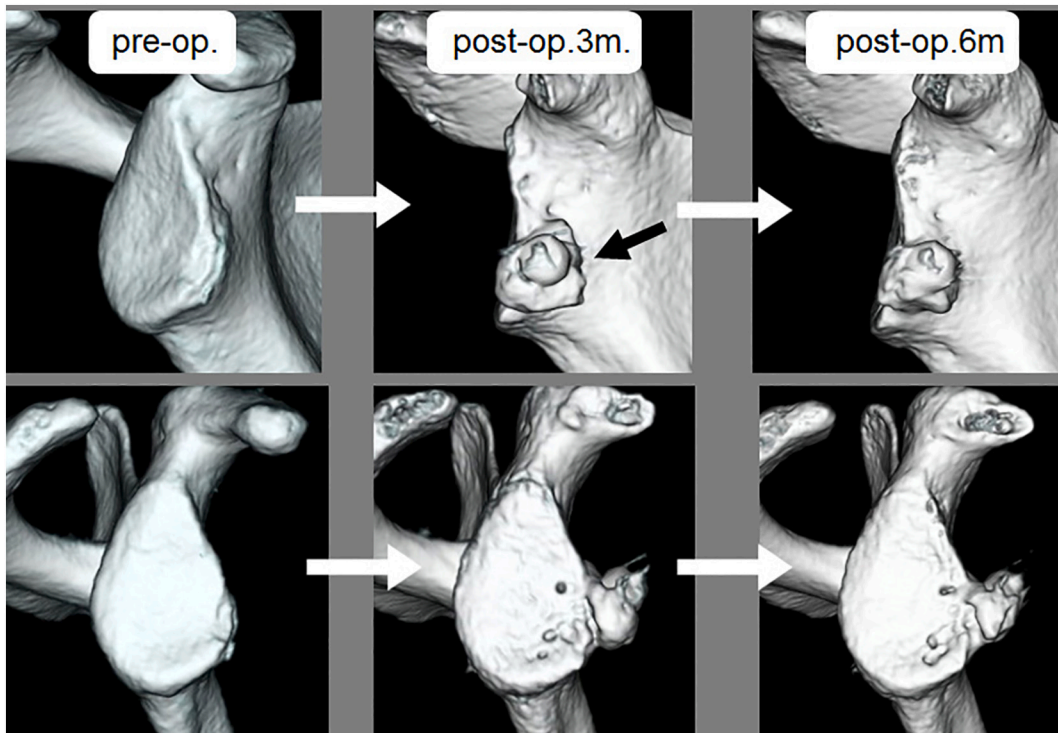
3D-CT images at pre-op., 3 and 6 months after op.: 1 shoulder showed the graft fixation at 70 degrees rotated position (black arrow), and the global bone resorption at 6 months.
